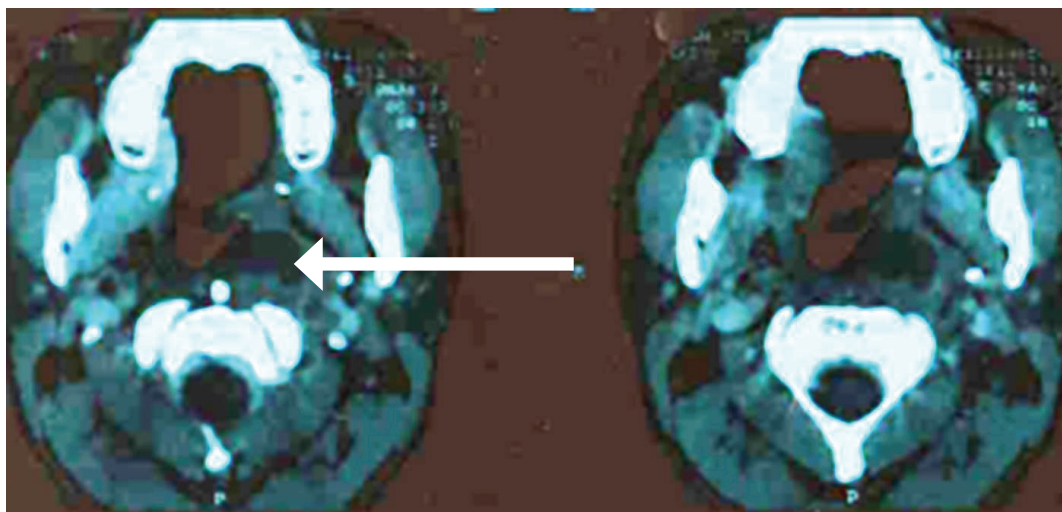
Axial CT scan shows a well-defined hypodense lesion in Left Parapharyngeal Space (White Arrow)
